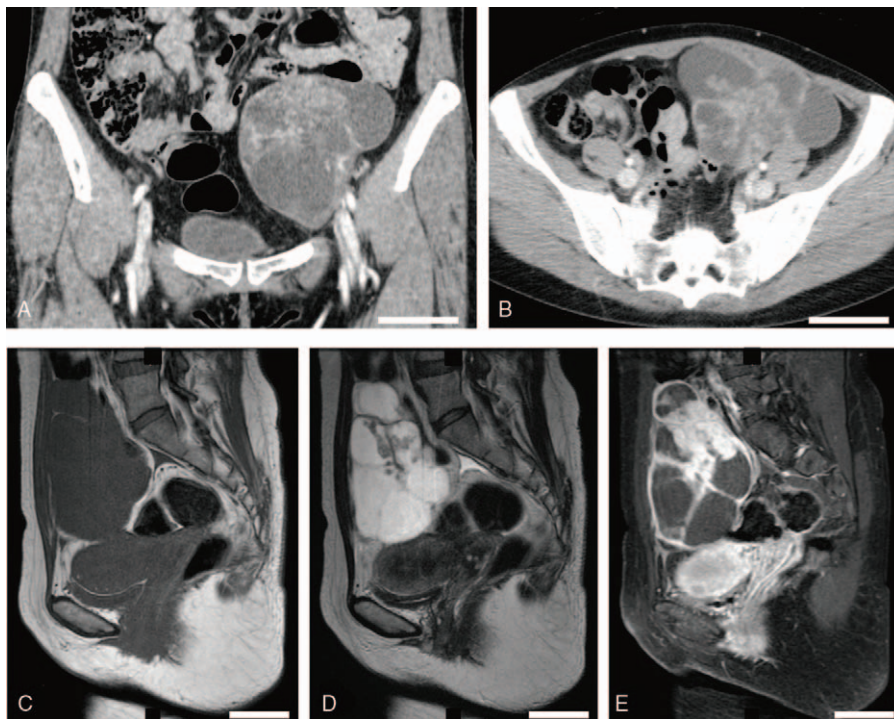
Radiographic images of the tumor. (A and B) Enhanced computed tomography images. A heterogeneously enhanced nodular lesion is present mainly in the left pelvic cavity (A). The tumor appears broadly connected to the anterolateral abdominal wall (B). (C–E) Magnetic resonance images of the sagittal planes. The tumor appears to connect to the posterior wall of the uterus and to the anterior abdominal wall. The tumor had low signal intensity on a T1-weighted image (C). High-signal-intensity areas with low-intensity lesions are seen on a T2-weighted image (D). A multilocular enhancement pattern with enhanced solid lesions is seen on a contrast-enhanced, fat-suppressed T1-weighted image (E). The white bars represent 5 cm.
